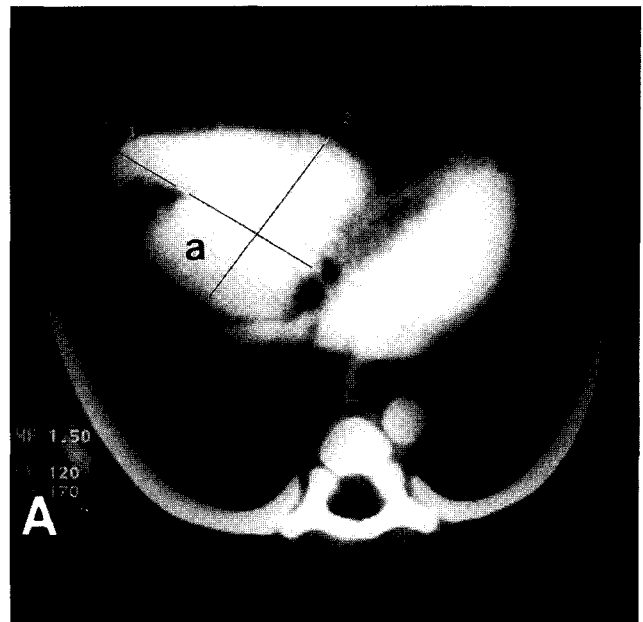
(A) Computed tomography of the chest shows right and accessory hepatic lobe(a) compressing the right ventricle of the heart. (B) Echocardiography displays external compression of the right ventricle(arrow) by a accessory hepatic lobe and the subsequent reduction of the right ventricle.
